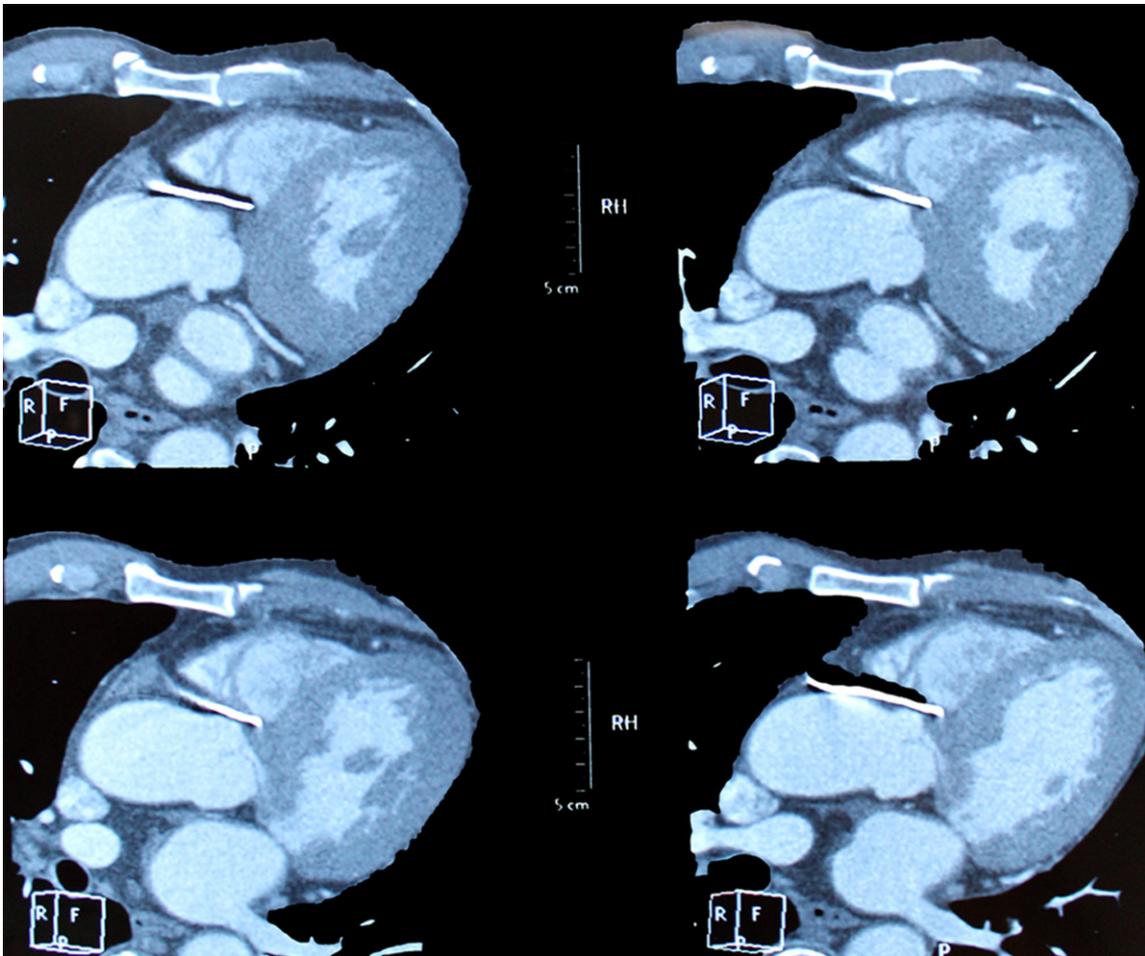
CT showing a ~5 cm high-density object anterior to the ascending aorta, with radiating artifacts, running from the upper-right to the lower-left.
